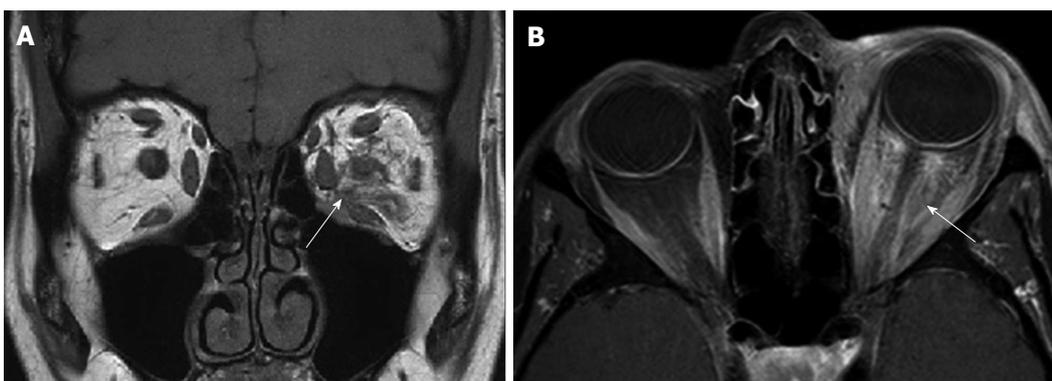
Diffuse cellulitic orbital inflammatory disease. A: Coronal T1-weighted image shows diffuse infiltration of the intraconal fat on the left (arrow); B: Axial fat-suppressed contrast-enhanced T1 shows diffuse enhancement throughout the intraconal fat. No well-defined focal mass or focal fluid collection is seen.
